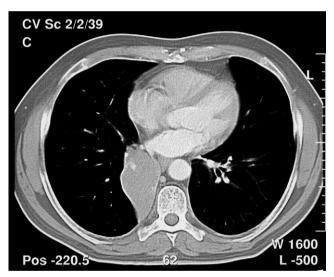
CT scan showing atelectasis of almost the entire right lower lobe.
